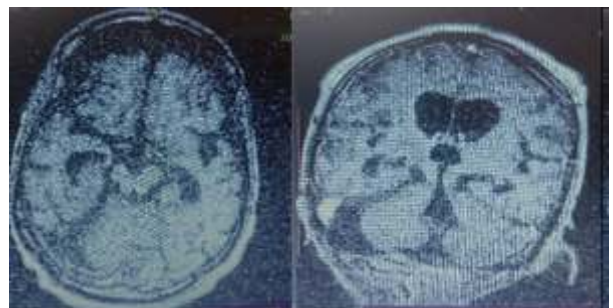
MRI at 3-week follow-up showing total resolution of subdural collections with marked bilateral frontal and temporal lobe atrophy and ventricular dilation.
